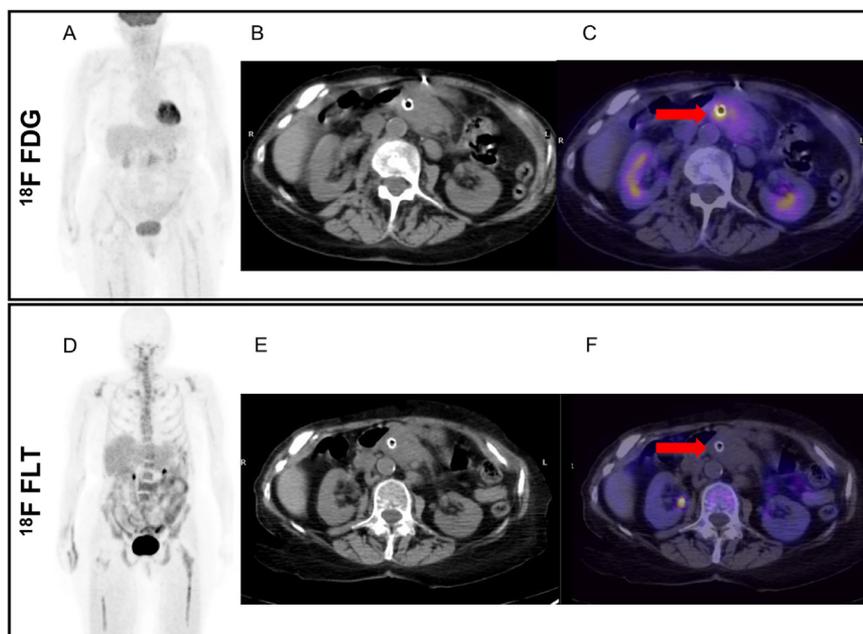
63-year-old woman with suspected recurrence of PDAC. FDG PET shows diffuse low-grade uptake along metallic stent (A, C), axial CT (B, E), and FLT PET (D), while FLT PET shows no uptake in the same area (F). Therefore, this was interpreted as inflammation rather than recurrent PDAC.
